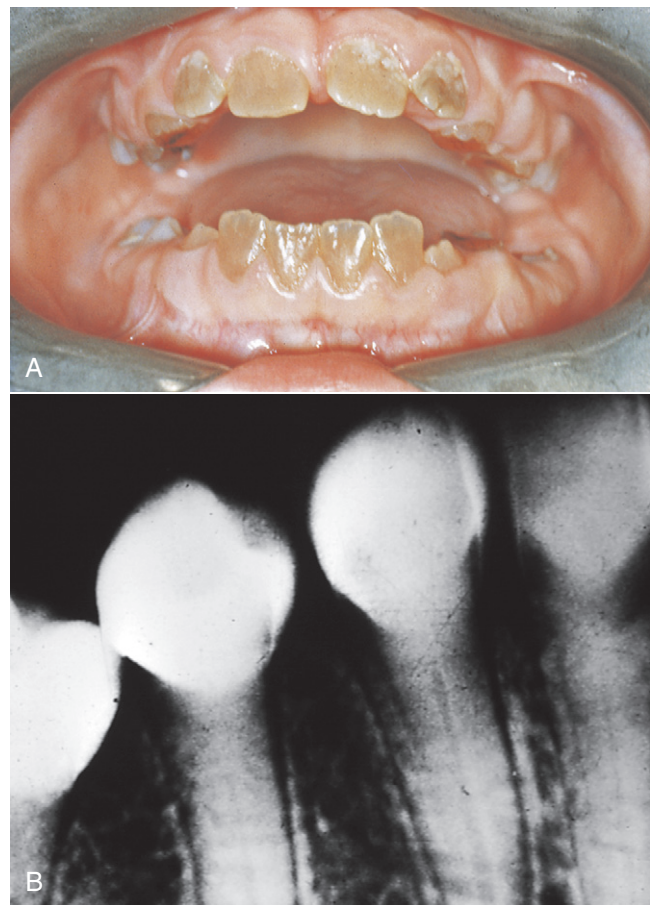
(A) Clinical and (B) radiographic appearance of dentinogenesis imperfecta. (From Ibsen O, Phelan J: *Oral pathology for the dental hygienist*, ed 5, St Louis, 2009, Saunders.)
